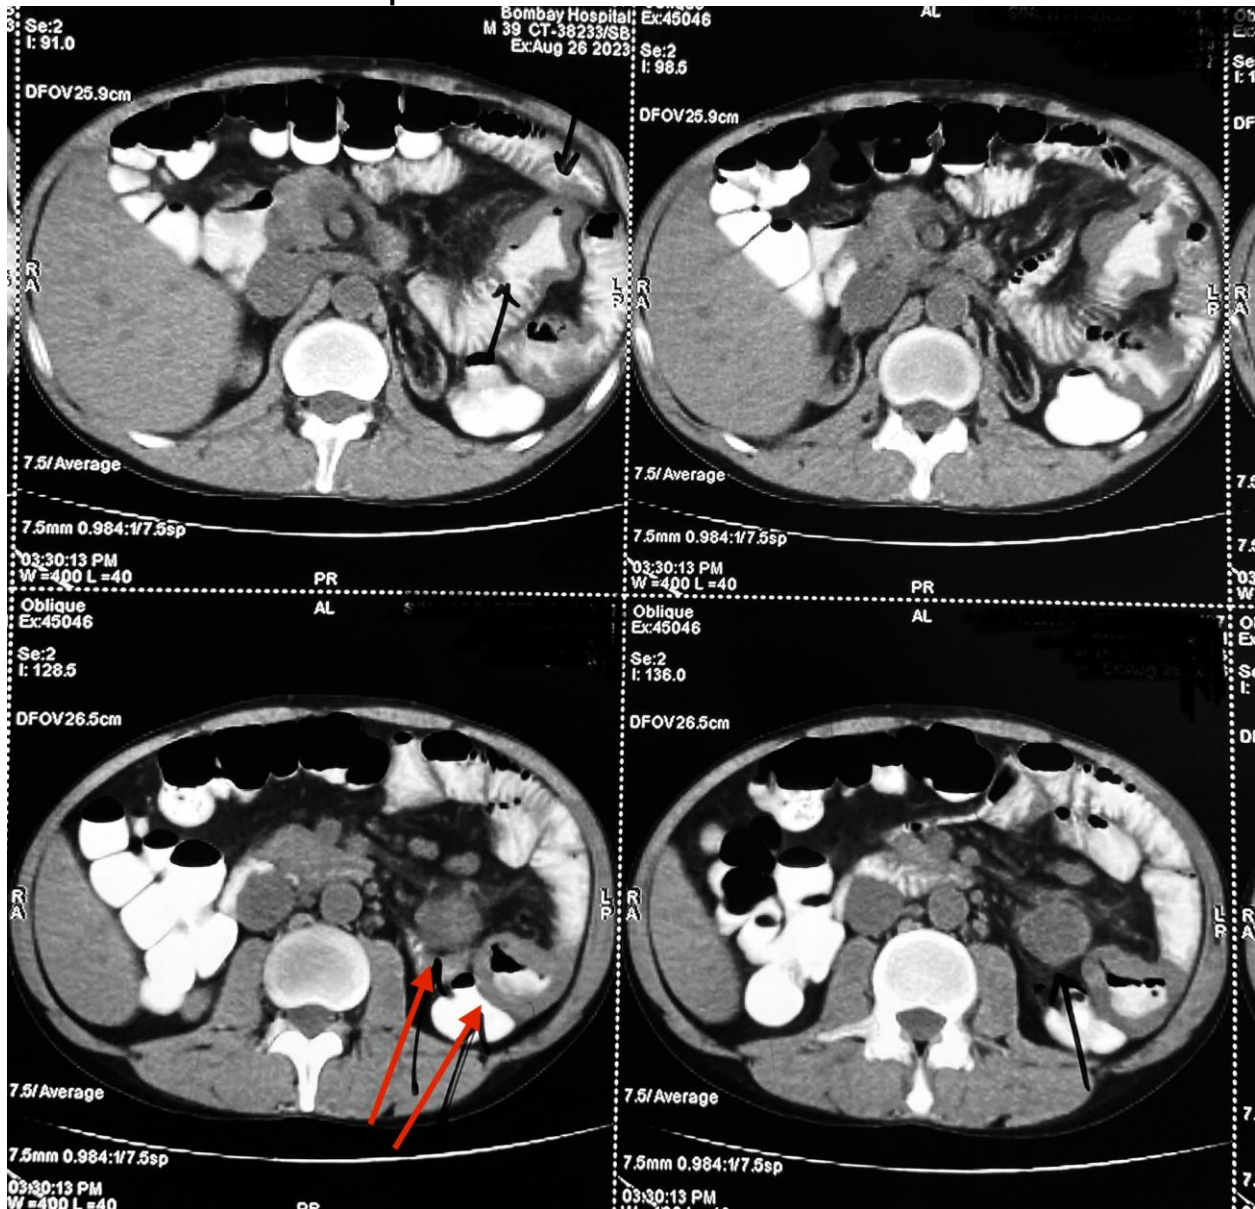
CT scan showing concentric mural thickening in jejunum.
